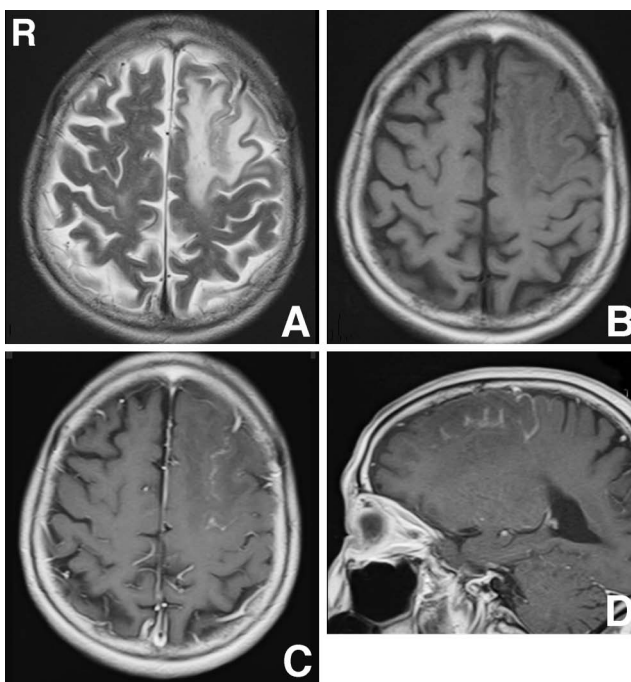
(A) Preoperative T₂-weighted magnetic resonance (MR) image demonstrating a high intensity lesion in the left frontal lobe. (B) Preoperative T₁-weighted MR image demonstrating a low intensity lesion. (C, D) T₁-weighted MR images with gadolinium showing mildly enhanced lesions.
